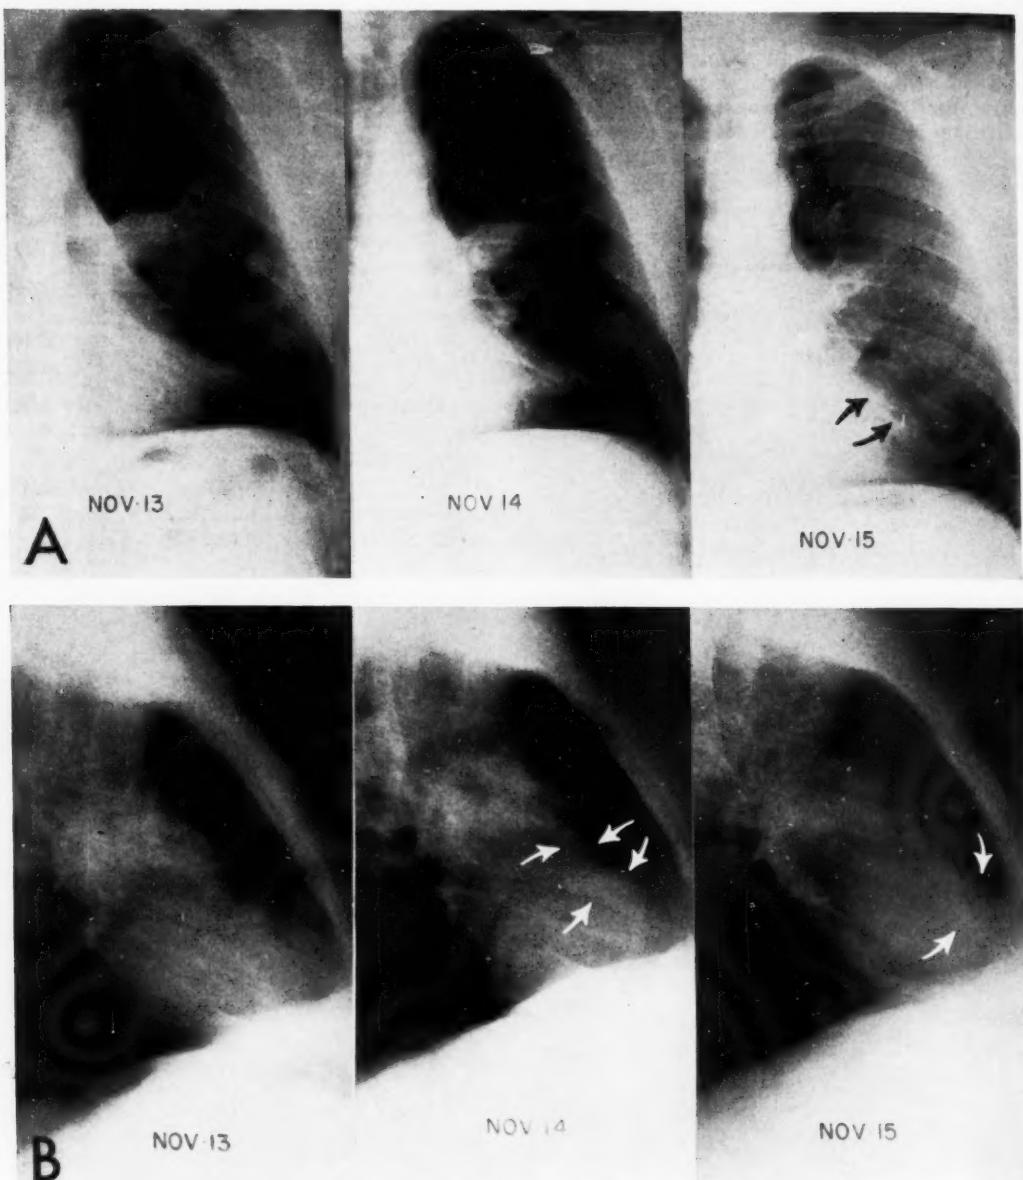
Serial roentgenograms of the chest of a 39 year old man admitted to hospital November 13th within 24 hours of the onset of symptoms of an acute respiratory infection. Sputum culture produced a heavy growth of *Diplococcus pneumoniae*:
